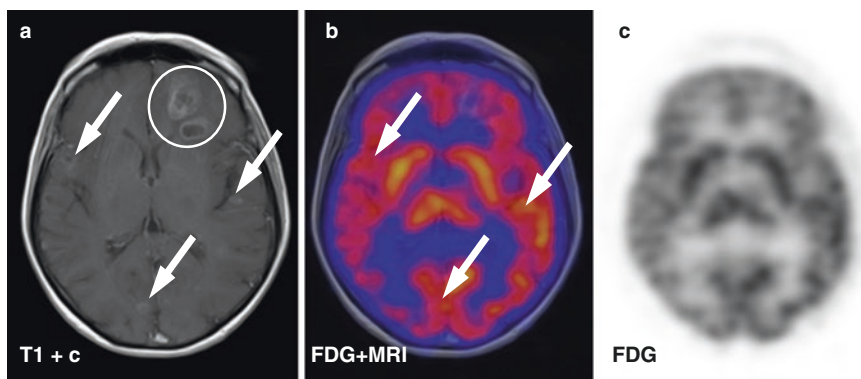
Treatment follow-up with FDG PET in a patient with multiple brain metastases. A 62-year-old female patient with multiple brain metastases of a small cell lung cancer. Gadolinium-enhanced MRI (a) was performed after WBRT and demonstrated multiple contrast-enhancing lesions, with two larger lesions frontally on the left side (white circle) and several smaller lesions (white arrows). FDG PET (b, c) demonstrated high physiological uptake throughout the brain but failed to clearly localize most contrast-enhancing MRI lesions as demonstrated by the white arrows on co-registration of FDG PET images with MRI (b). This case demonstrates the lack of diagnostic sensitivity of FDG PET for treatment response evaluation in brain tumors
